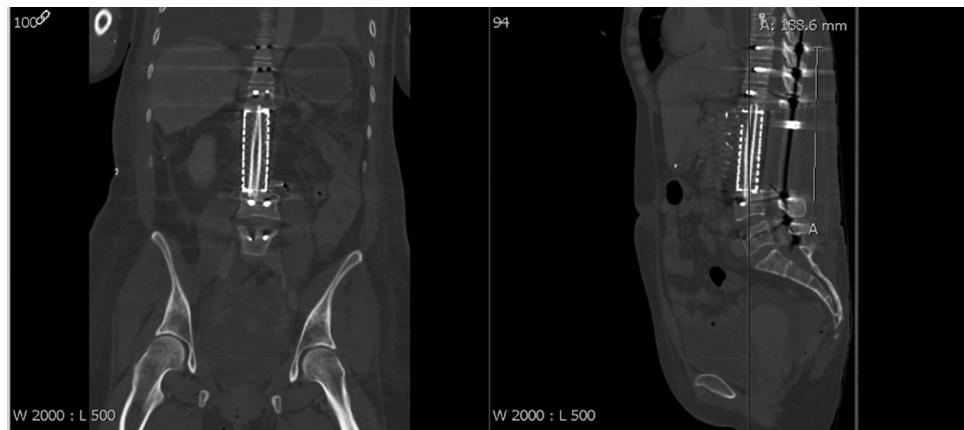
Post operative CT scan of Synmesh cage and vascular fibula construct placed in the lumbar spine after en bloc resection. Left Coronal CT scan Cut and Right Sagittal CT scan cut. Reproduced with permission from Hatchell et al. [88].
